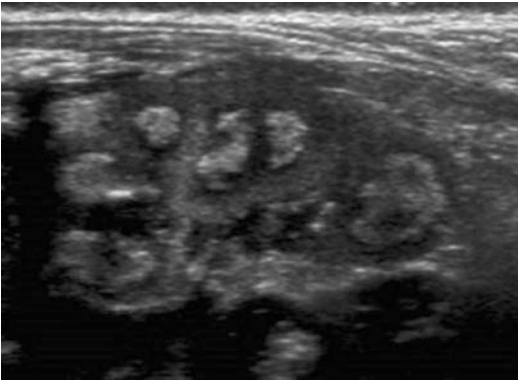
Diffused renal medulla ischemia—Ultrasound. Sagittal scan through the right kidneys displaying hyper-echoic pyramids due to hemorrhage
